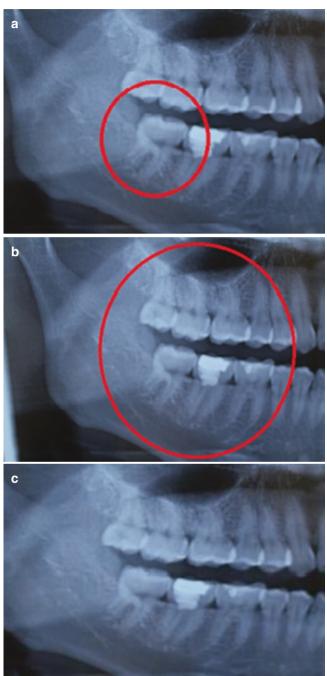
(a) The dental alveolar bone septum and alveolar ridge between the mesial root of a normally positioned mandibular wisdom tooth and the distal root of the second molar is indicated in the red circle. (b) The dental alveolar bone septum and alveolar ridge between the mesial root of a normally positioned upper and lower wisdom teeth and the distal root of the second molars on the same side is indicated in the red circle. (c) It is necessary to evaluate the surrounding structures of the wisdom tooth and the opposing teeth when judging clinically whether it is in a normal position or not. It is also important to evaluate the intraoral X-ray films or, even better, the panoramic radiography
